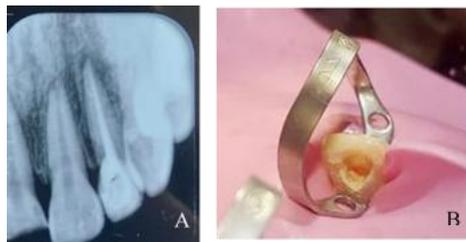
Obturation. A: Radiographic View. B: Clinical View
